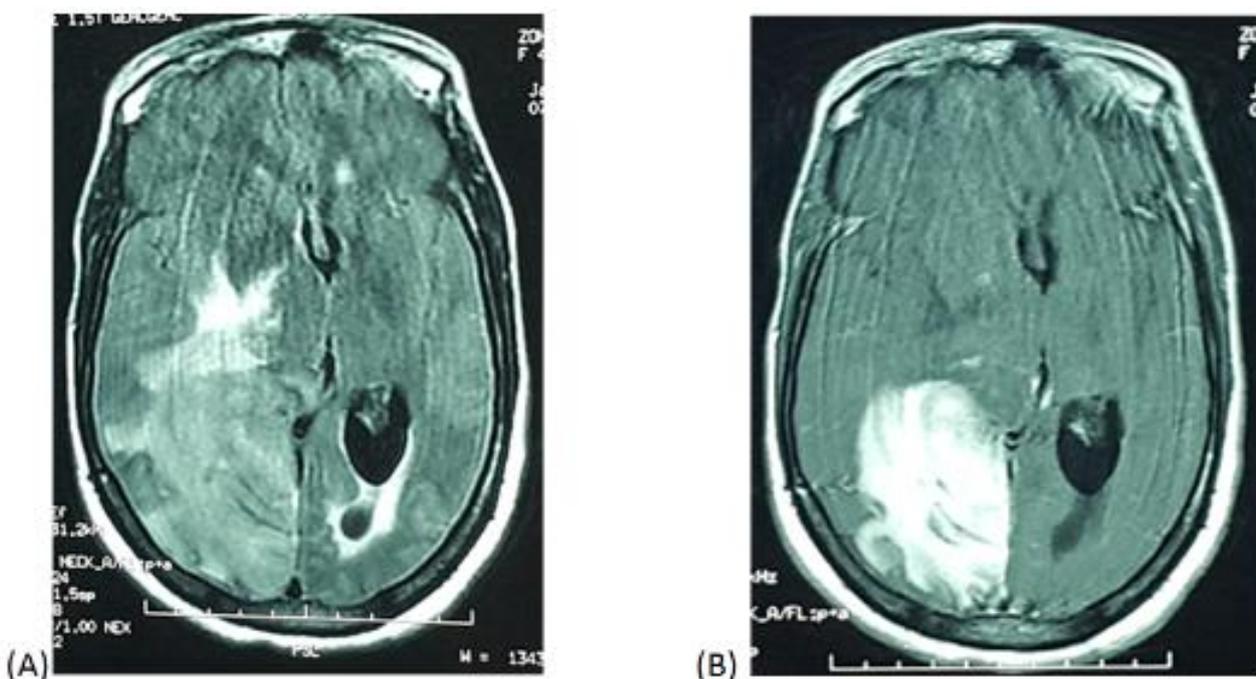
Cerebral magnetic resonance imaging (MRI) showed isointense on T1(A), with intense and homogenous contrast enhancement (B).
